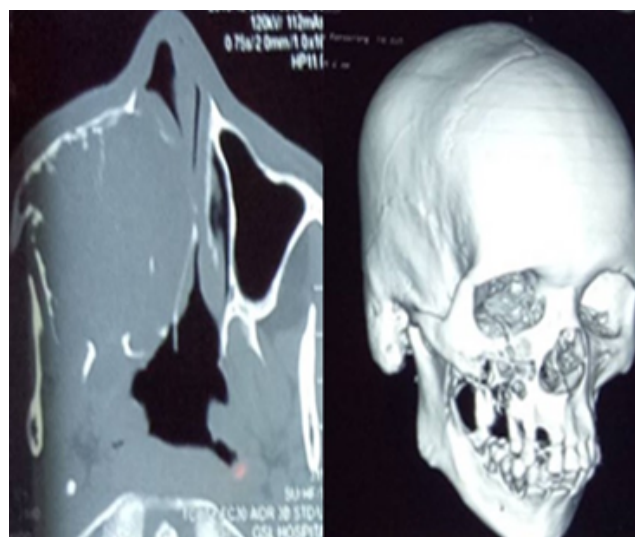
Computed tomography (CT) and 3d bone CT images showing perforation of cortical plates.
